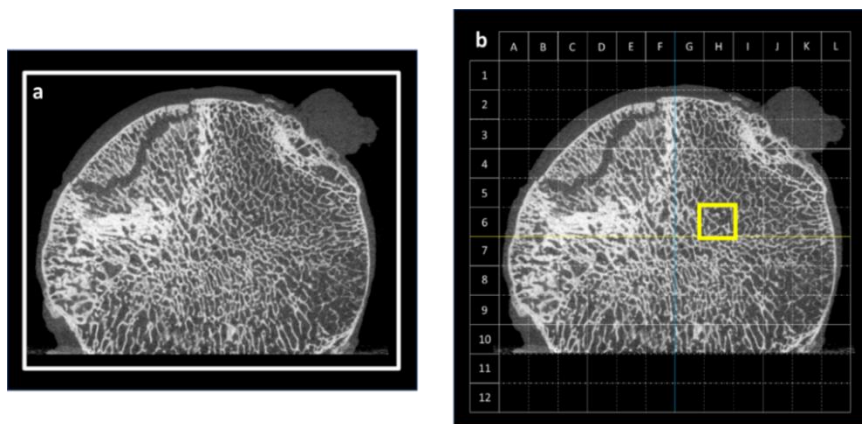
Coronal μ CT reformat of an osteonecrotic femoral head without (a) and with (b) grid overlaying. Each grid box was analyzed for the presence or absence of defined bone changes including microfractures, sclerosis and resorption. The highlighted H6 grid box contains normal trabecular bone. The same process was performed for MDCT reformats (not shown).
